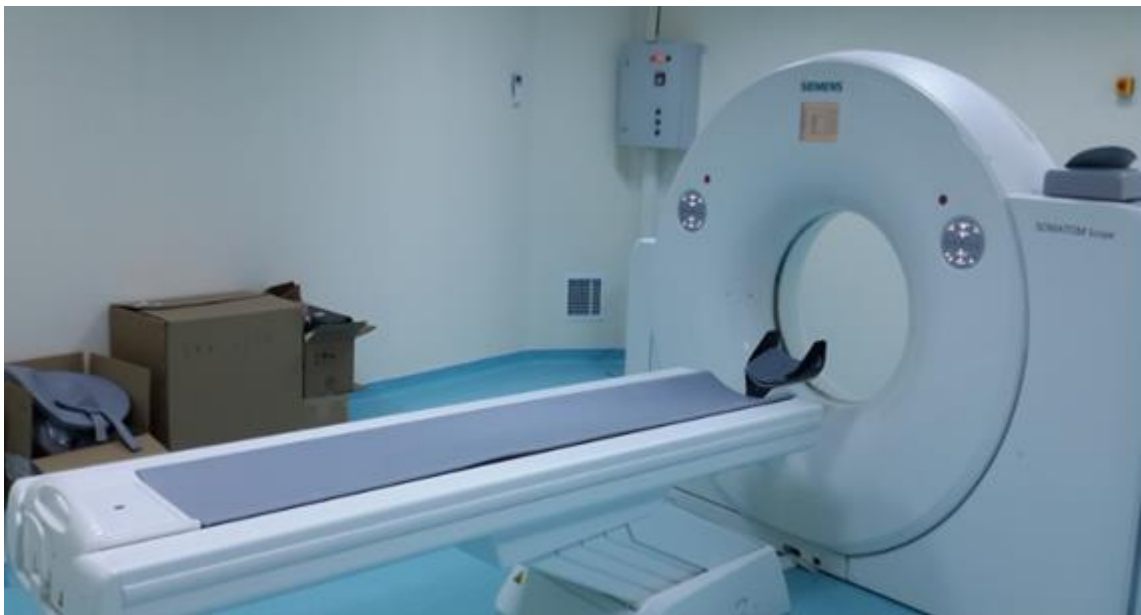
Siemens SomatomEmotion 16 Slice Multi-slice Computed Tomography
